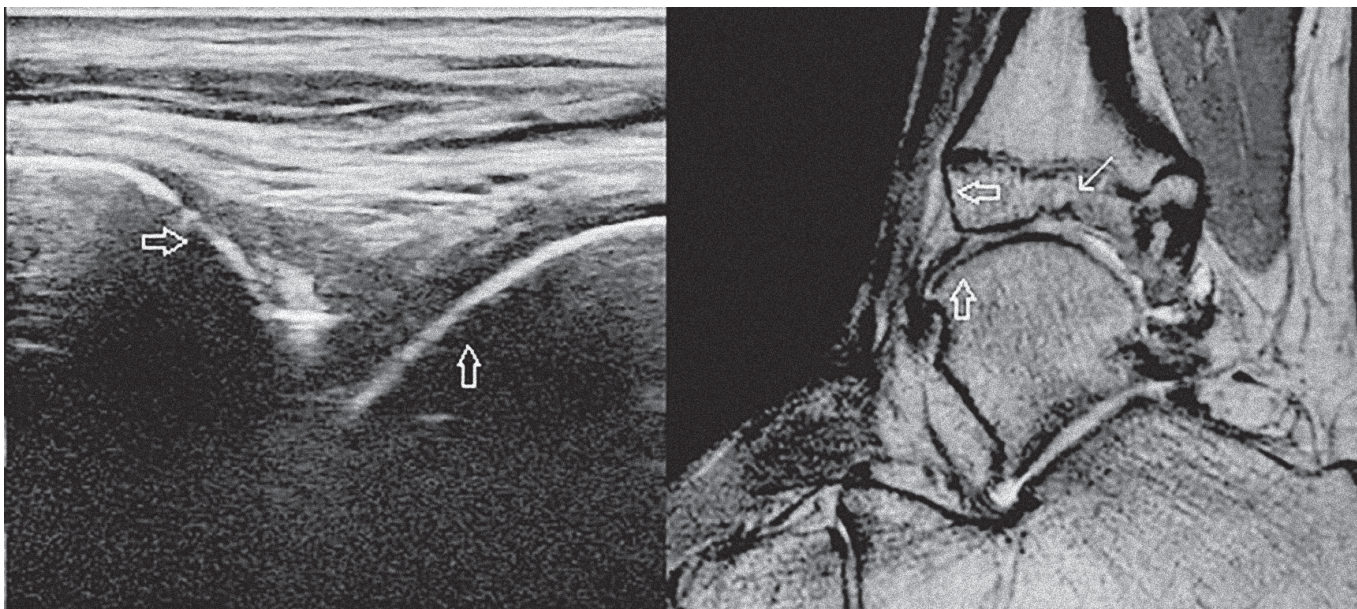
An example of a discordance between US and MRI. An US image of the tibiotalar joint in the sagittal plane is shown on the left, a PD weighted MR image of the same ankle in the sagittal plane is shown on the right for comparison of the corresponding structures. In both images, the smooth surface of the tibial cortical bone is marked by the horizontal hollow arrow and the smooth surface of the talar cortical bone is marked by the vertical hollow arrow. MRI demonstrates an osteochondral defect at the tibial side of the talocrural joint (white arrow), which is outside of the visualization area of US.
